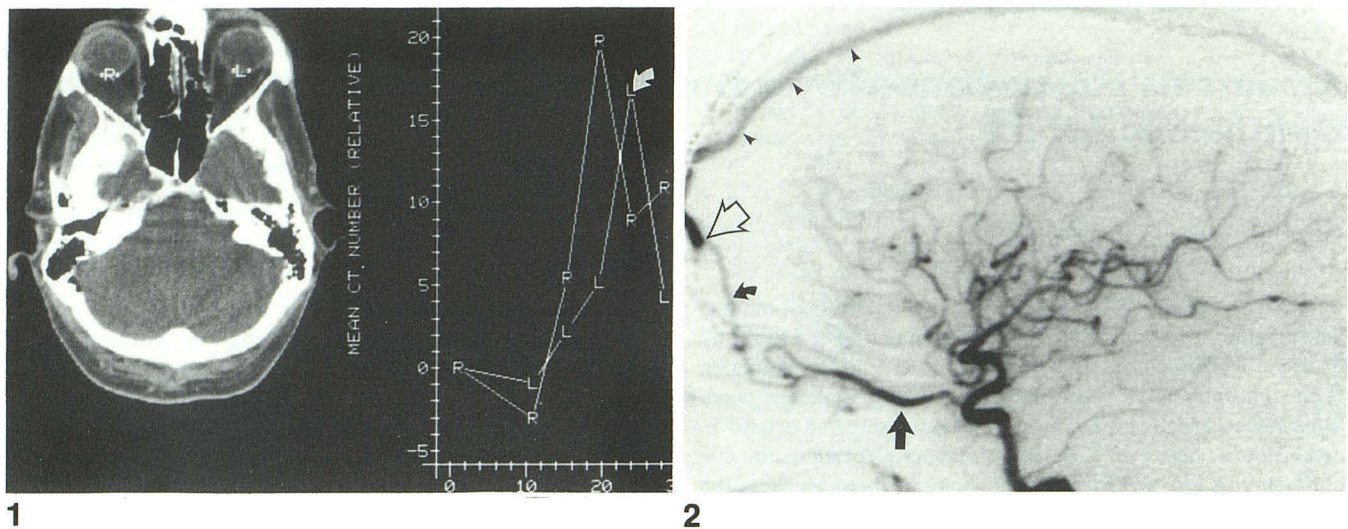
Intravenous bolus contrast-enhanced dynamic orbital CT revealing a delay in the peak (arrow) of the time-density curve of the left optic head (L) as compared with the right (R).
